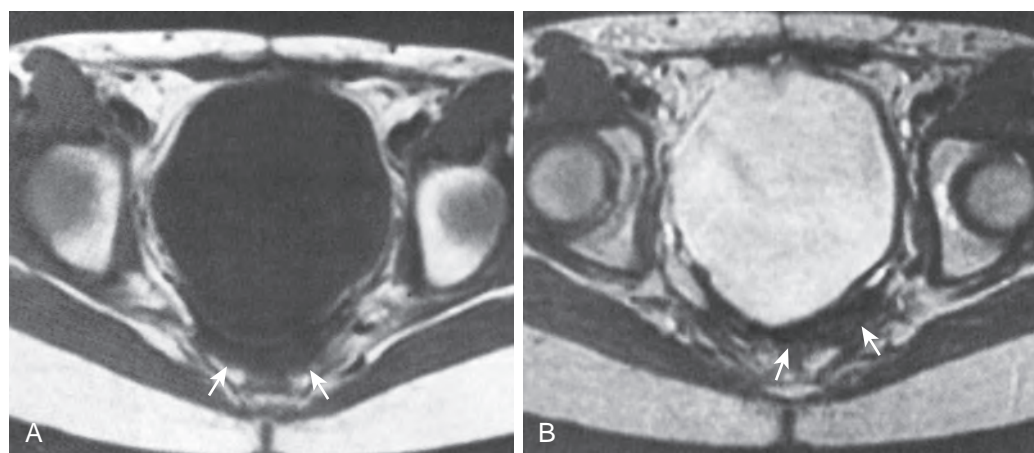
MRI of a postsurgical scar in patient with total colectomy. A. T1-weighted spin-echo image (600/11). Area posterior to the bladder has low signal intensity (arrows). B. T2-weighted spin-echo image (2500/80). Low signal intensity area on T1-weighted image remains dark (arrows) on T2-weighted scan, suggesting fibrosis in the surgical bed.
